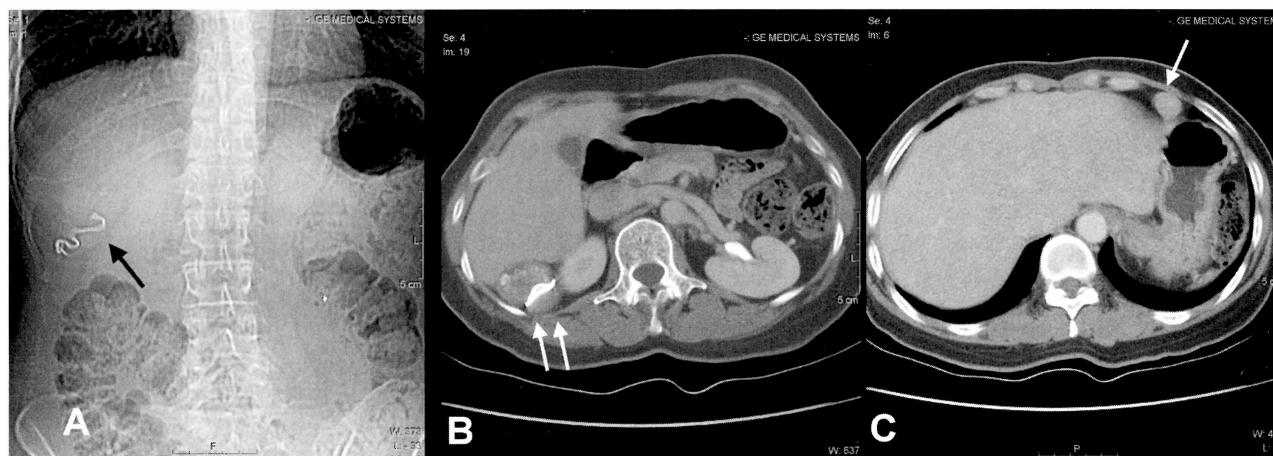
(A) Plain abdominal film delineated retained gauze (black arrow) located in the right subhepatic region in the right upper abdomen. (B) Transaxial CT image at the lower level revealed a granuloma with gauze (gossypiboma, white arrows) located dorsal to segment 6 of the liver. (C) Post-contrasted abdominal CT study transaxial image disclosed a metastatic nodular lesion in the left upper abdomen (white arrow), just ventral to the hepatogastric ligament region.
